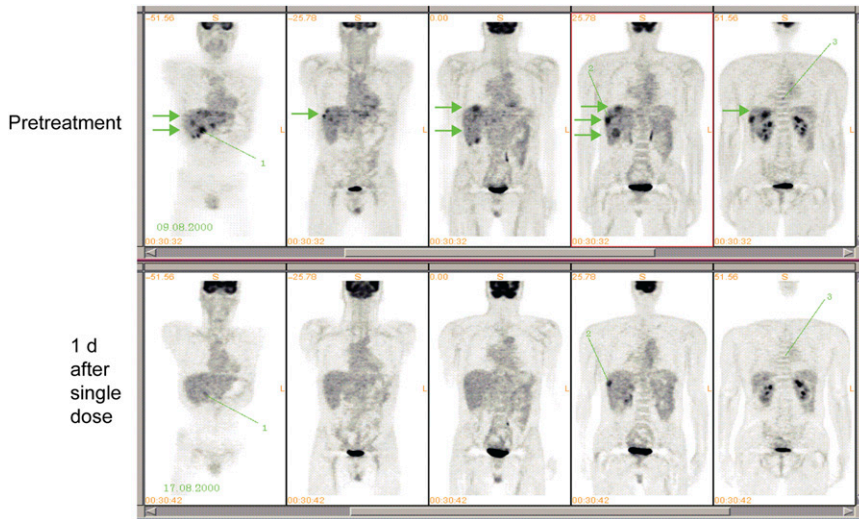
Multiple coronal ^{18}F -FDG PET images of patient with GIST before (top) and 1 d after (bottom) treatment with imatinib mesylate. Arrows show liver metastases that rapidly changed on imaging; lines show lesions that did not. (Courtesy of Heikki Joensuu, Turku PET Center, Department of Oncology, Helsinki University Central Hospital, Helsinki, Finland.)
